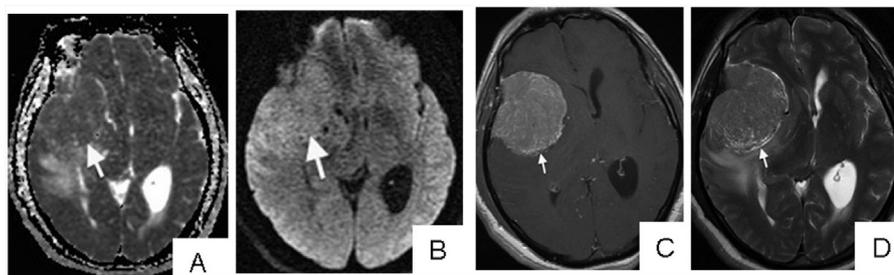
Patient 9 with meningioma. A. Apparent diffusion coefficient (ADC) map. B. Diffusion weighted imaging (DWI). C. Post gadolinium T1. D. T2 images, which is an atypical grade II meningioma that had a higher mean ADC value of 1052.1 mm²/s.
